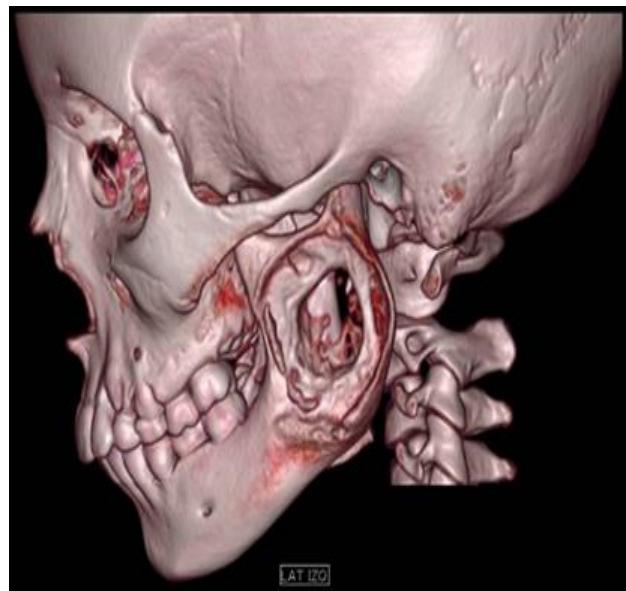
CT with 3D reconstruction, in which a lytic lesion involving the ascending branch and mandibular angle is observed.
